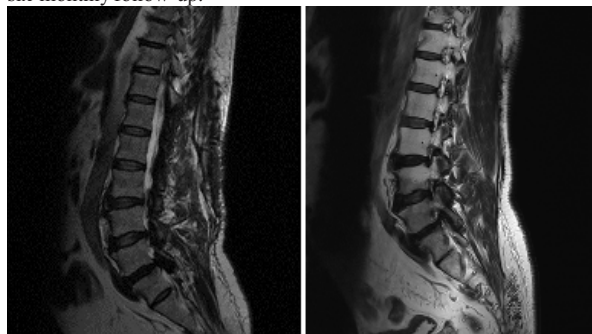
Pre- and post-radiotherapy sagittal T2-weighted MRI of spinal ependymoma. (A) Pre-radiotherapy sagittal T2-weighted MRI demonstrating a well-defined altered signal intensity lesion measuring approximately $40 \times 9 \times 7$ mm, located inferior to the conus medullaris at the L1-L2 vertebral level. The lesion shows central T2 hypointensity with a peripheral hyperintense rim, consistent with recurrent disease in a known case of spinal ependymoma. (B) Post-radiotherapy sagittal T2-weighted MRI showing no evidence of residual or recurrent lesion at the previously involved site. Only post-radiotherapy changes are noted, with resolution of the prior mass effect and no abnormal focal signal intensity suggestive of active disease.
